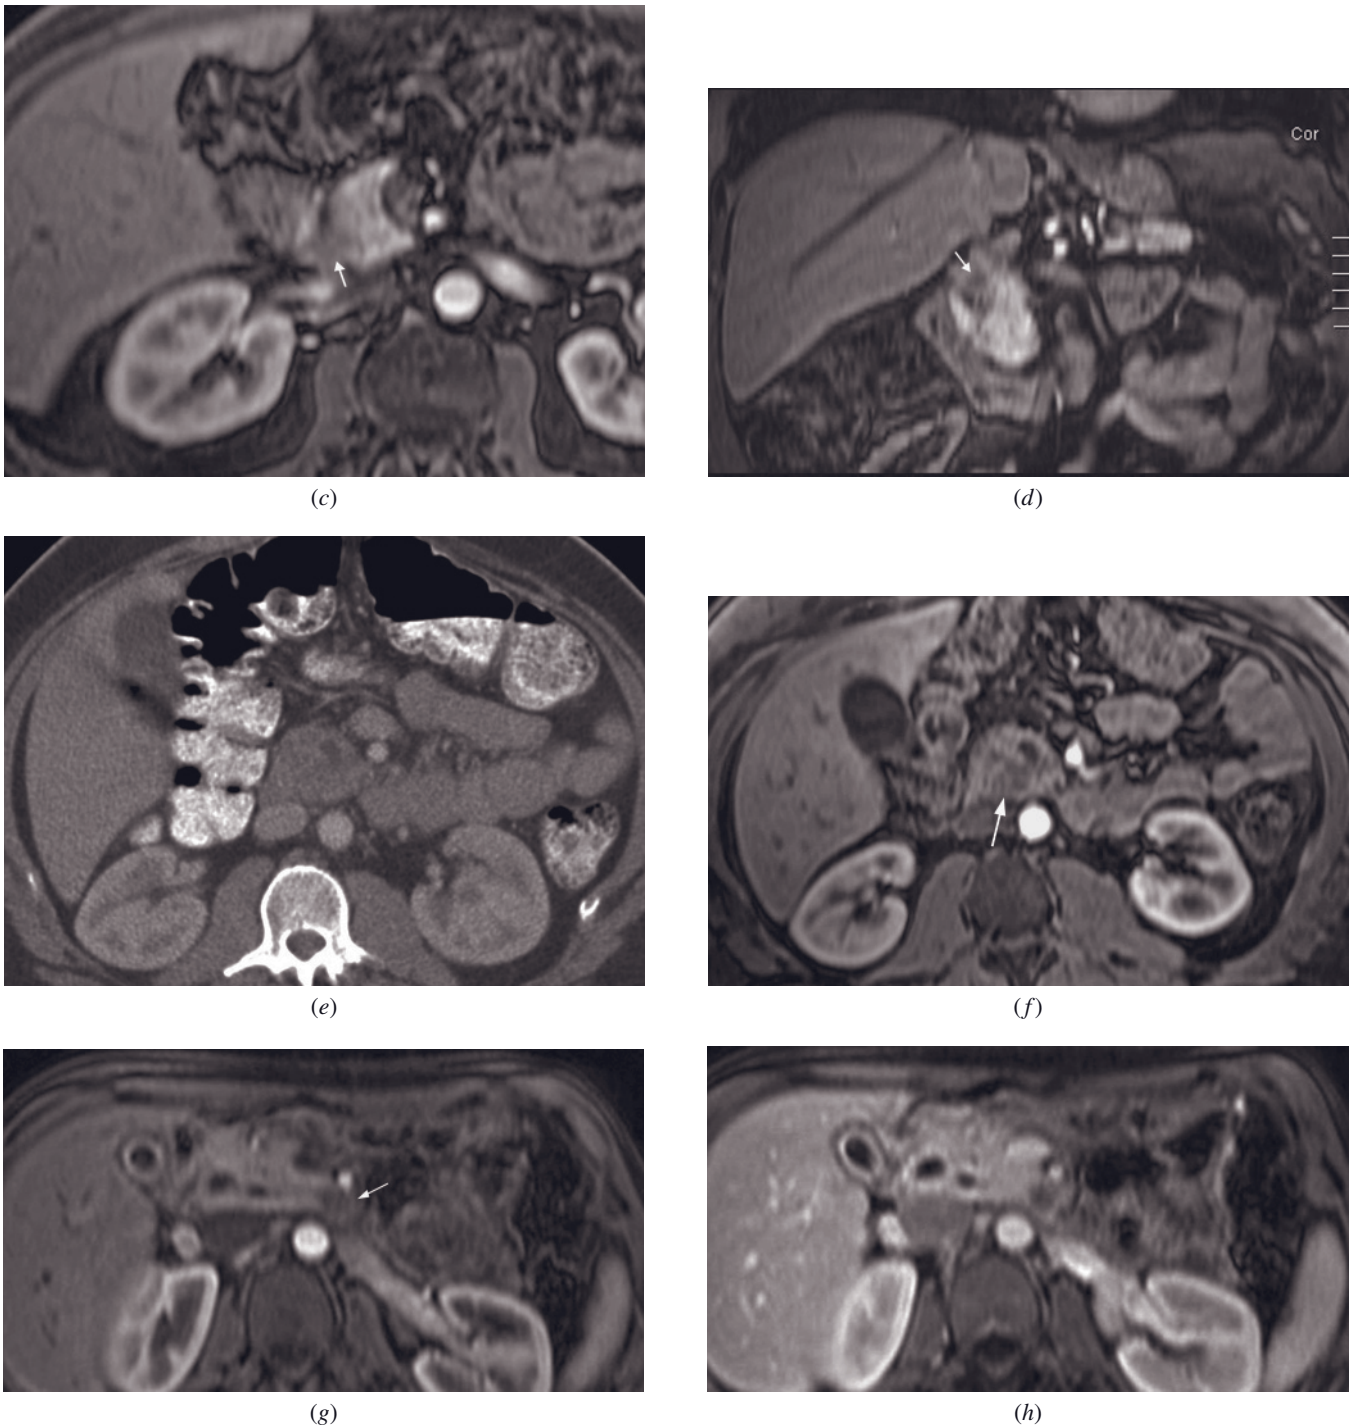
(Continued) the immediate postgadolinium fat-suppressed T1-weighted 3D gradient-echo (*d*) images in a patient with small pancreatic cancer. A small cancer is present in the pancreatic head (arrows, *c*, *d*), which is most clearly defined as a mass with demarcated borders on fat-suppressed T1-weighted images (arrows, *b*). The small, non-organ-deforming tumor is not apparent on CT image. The tumor appears as a hypo-enhancing mass (arrow, *c*) on the immediate postgadolinium image (*c*) with demarcated margins. Dynamic contrast-enhanced CT (*e*) and immediate postgadolinium fat-suppressed T1-weighted 3D gradient-echo (*f*) images in a second patient. A small cancer seen on the immediate postgadolinium image (arrow, *f*), is not appreciated on CT image.
